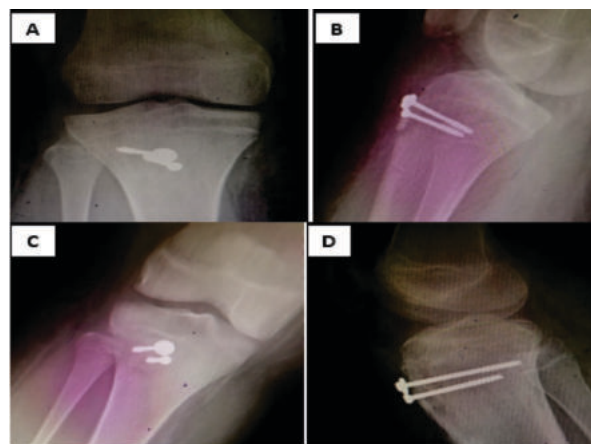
2nd (A and B) and 3rd (C and D) month follow up radiographs.
